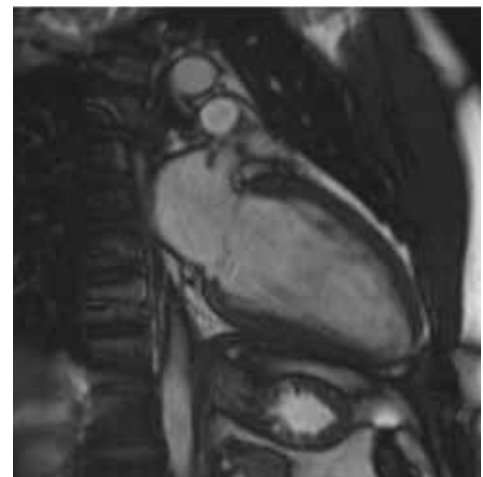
Cardiac magnetic resonance image of patient's phenotype-negative son.
